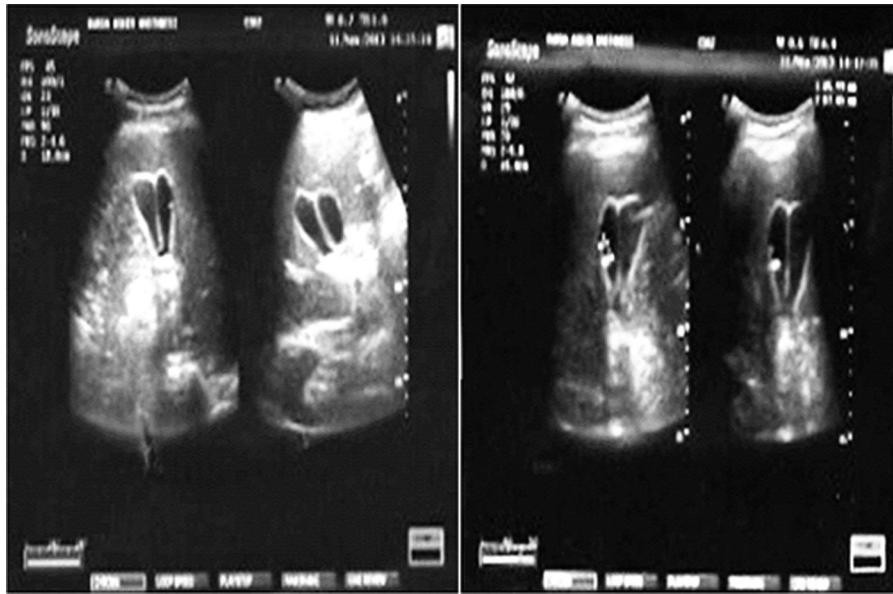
Abdominal ultrasonography showed that the patient has two separated gallbladders and also has two cystic ducts.
